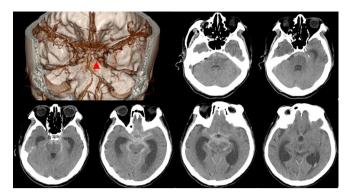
Brain computed tomography on post-admission day 8 shows a subarachnoid hemorrhage around the basal cistern and newly developed cerebral aneurysm (arrowhead).
